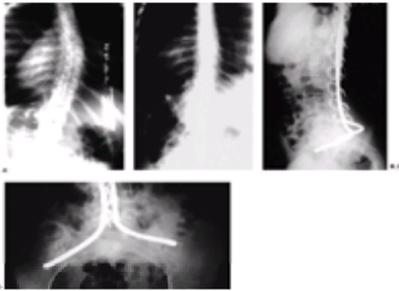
A: Sitting posteroanterior spinal radiograph of an 18-year-old woman with spinal muscular atrophy. A slowly progressive scoliosis has affected her wheelchair sitting balance. B: Postoperative radiograph after posterior spinal fusion and Luque rod instrumentation using the Galveston technique provided almost complete correction of the spinal deformity. Thirteen years postoperatively she functions independently despite the subsequent need for a tracheostomy and ventilator support. C: Lateral view demonstrates preservation of lumbar lordosis, which is important for proper sitting balance. D: Anteroposterior view of the pelvis shows proper positioning of the Luque rods in the ilium. They should penetrate as far into the ilium as possible for maximum strength.
